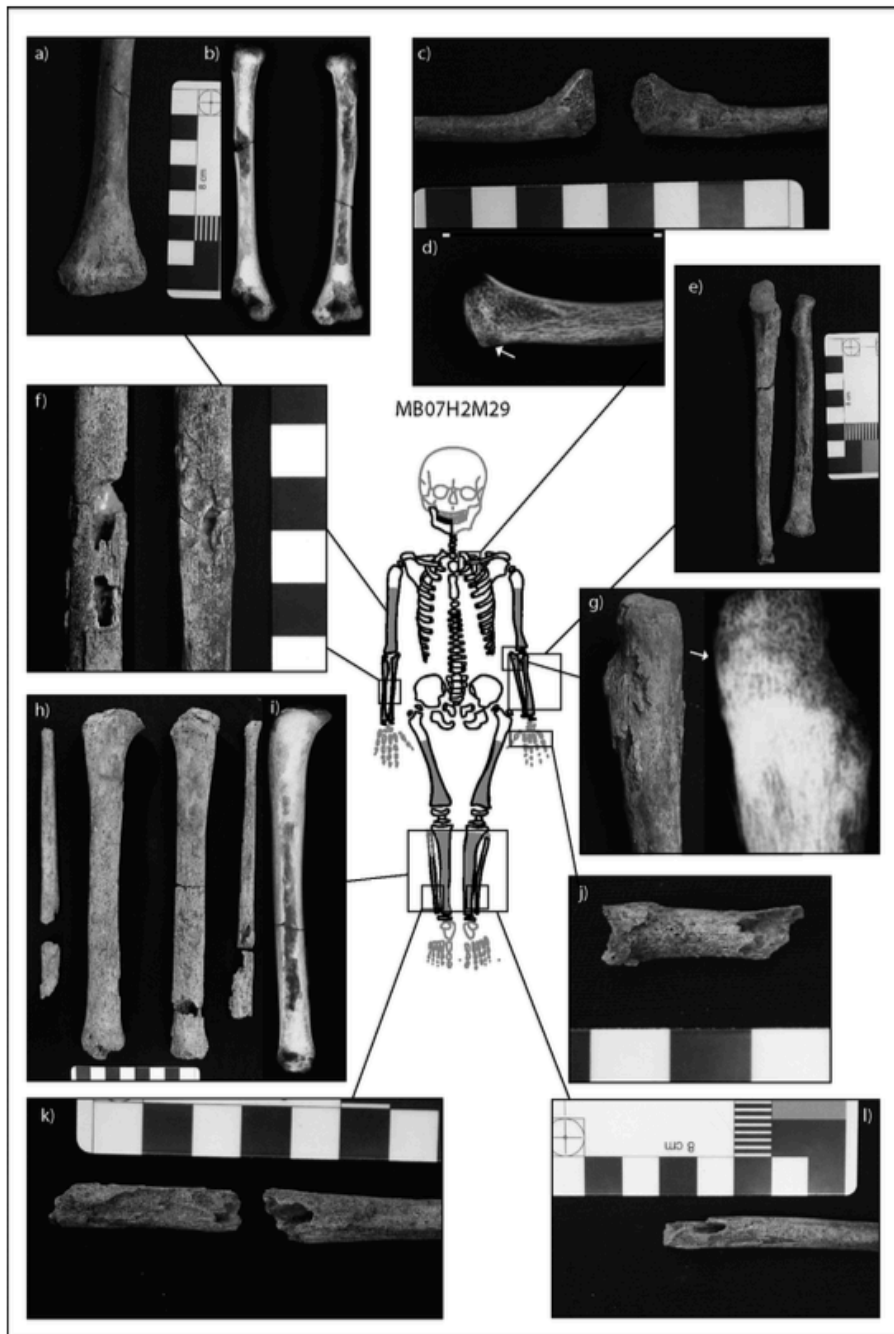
Expression of lesions related to infectious disease in M29. Preserved bones are outlined in black, with absent bones outlined in light gray. An undetermined metacarpal is also present but not demonstrated in the figure, as its skeletal position is unknown. The skeletal extent of osteoblastic lesions is indicated by dark gray fill. (a) Subperiosteal new bone deposit on the distal shafts and metaphyses of the humeri. (b) There are slight cortical enlargements visible on radiographs throughout the humeral shafts. (c) Remodeled enlargement of the medial left clavicle. The metaphyseal plate is bulging. (d) Radiographs do not demonstrate a distinct cortical enlargement of the left medial clavicle. The internal trabeculae appear radiolucent, and a distinct oval lytic lesion with a radiodense sclerotic margin is present on the inferior margin of the medial metaphysis. Some increased calcification is present on the medial metaphyseal plate. (e) Diffuse subperiosteal new bone deposit across the radii and ulnae. (f) Two oval cavitations within nodes of new bone on the midshafts of the right radius and ulna. While significant damage has occurred to the lesion floor, the margins of the lesion are preserved and indicate superficial cavitation. (g) Large node of new bone on the proximal left ulna. Radiographs demonstrate a small oval lytic lesion with sclerotic margins within the node. (h) Proliferative subperiosteal new bone across the tibiae and fibulae. Fibular cortical enlargements are thickest toward the distal shaft. Note the rounded margins of the anterior shaft of the tibiae indicating saber shin deformity. (i) Radiograph of the right tibia demonstrating cortical enlargement of the anterior crest indicating saber shin. (j) An unknown metacarpal with significant postmortem damage. However, it is clear that the entire shaft of the metacarpal has undergone prolific pathological change indicative of dactylitis. The internal margins of the cortex are porous. (k) and (l) Focal cavitations of the right and left distal fibulae. Margins of the lesions are smooth and within nodes of new bone. The surrounding bone has undergone complete prolific pathological change with the internal cortex appearing porous. Osteoblastic lesions considered in the diagnosis of nutritional disease are presented in Figure 4. (Image: M. Vlok)
